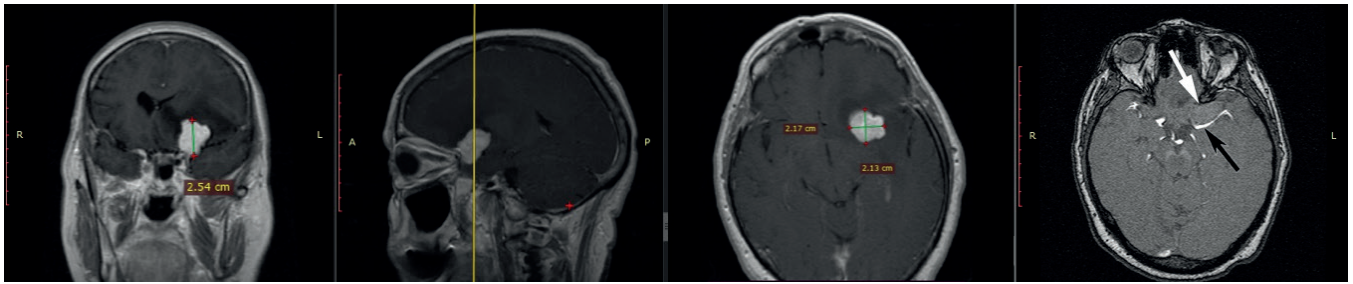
Preoperative brain magnetic resonance images (MRI) with Gadolinium demonstrated a $2.1 \times 2.2 \times 2.5$ cm³, extra-axial enhanced mass in the inner third of sphenoid wing with irregular shape. The mass (white arrow) encases middle cerebral artery (black arrow)
